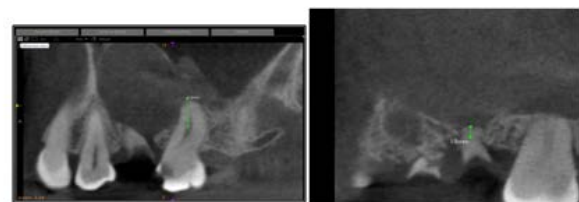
Measurement of CBCT Images
